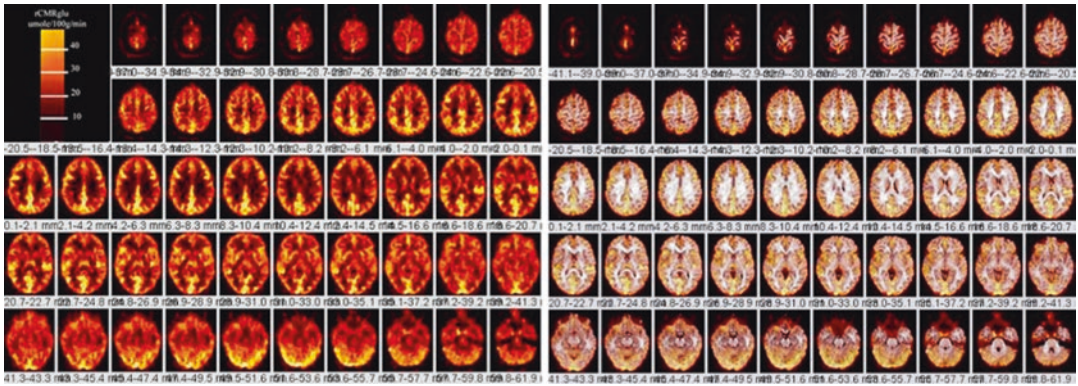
Left.* 18F-FDG PET scan sections through the brain (*left*) and corresponding PET–MRI co-registered fusion images (*right*). Images are from a 36-year-old normal female volunteer who underwent fully dynamic 18F-FDG PET with arterial sampling at rest. Regional cerebral metabolic rates of glucose utilization expressed as rCMRglu in units of micromole/100 g/min (*color bar*). PET images are registered to a spoiled gradient echo (SPGR) MRI volume data (1-mm-thick MR sections) that
